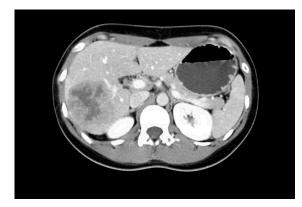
A computed tomography scan with nonionic contrast confirmed a mass located in the posterior right lobe within segments VI-VII and measuring 7.2 cm \times 6.0 cm. The lesion demonstrated peripheral enhancement with central necrosis but no evidence for portal vein invasion. The hepatic veins were patent and no biliary dilatation was observed. No pulmonary lesion was highlighted.
